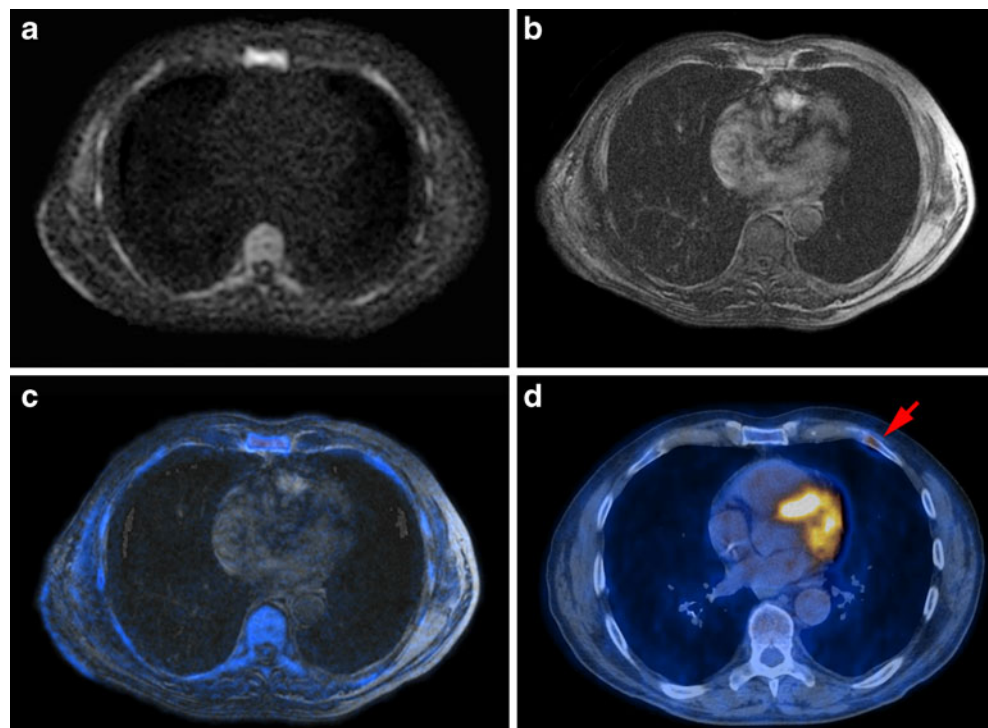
A 69-year-old male patient with metastases in the rib from colorectal cancer. WbDWI (a), wbT2(b), and fused images (c) showed no evidence of malignant lesion. This lesion was missed on wbDWI, wbT2, and fused images. The reference standard PET/CT showed clear FDG-uptake in a left anterior rib consistent with an osseous metastasis (d)
